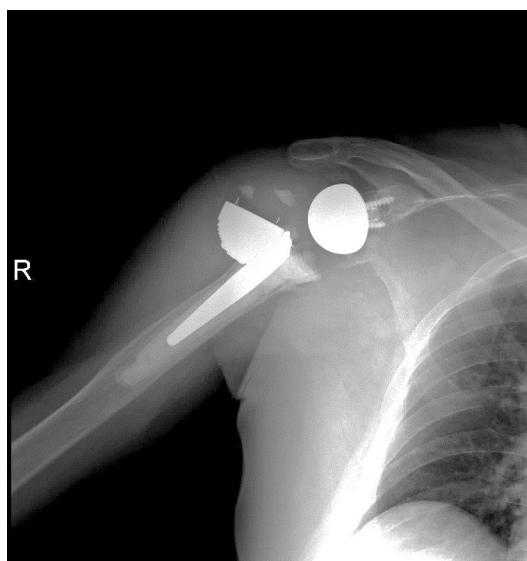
Plain radiographs of the right shoulder.
